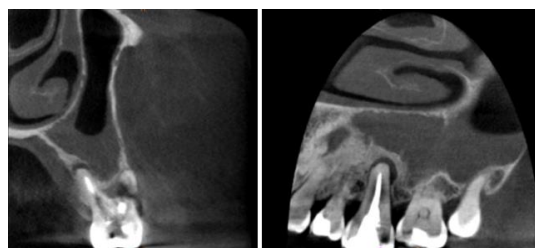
Sagittal and coronal sections of the CBCT scan.
